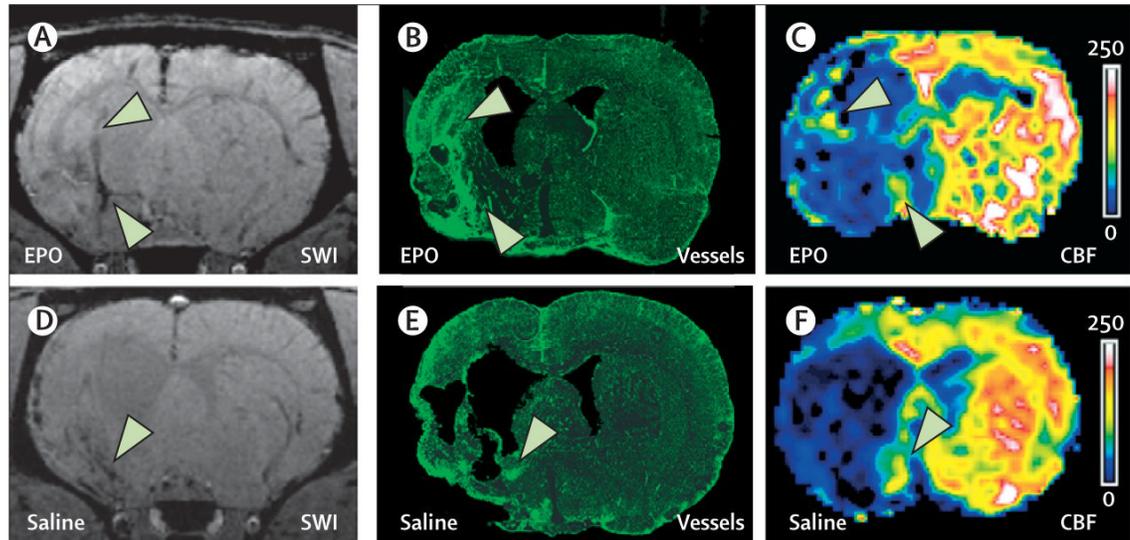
Cerebral angiogenesis identified with MRI and confocal images
